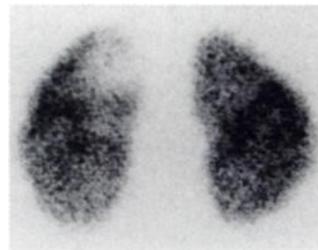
DMSA scintigraphy (posterior view) in child with acute pyelonephritis. Large hypoactive area in the upper pole of left kidney. Percentage of $^{99\text{m}}\text{Tc}$ -DMSA uptake is 48% left and 52% right. Overall clearance with ^{51}Cr -EDTA is $153\text{ mL/min/1.73 m}^2$.
